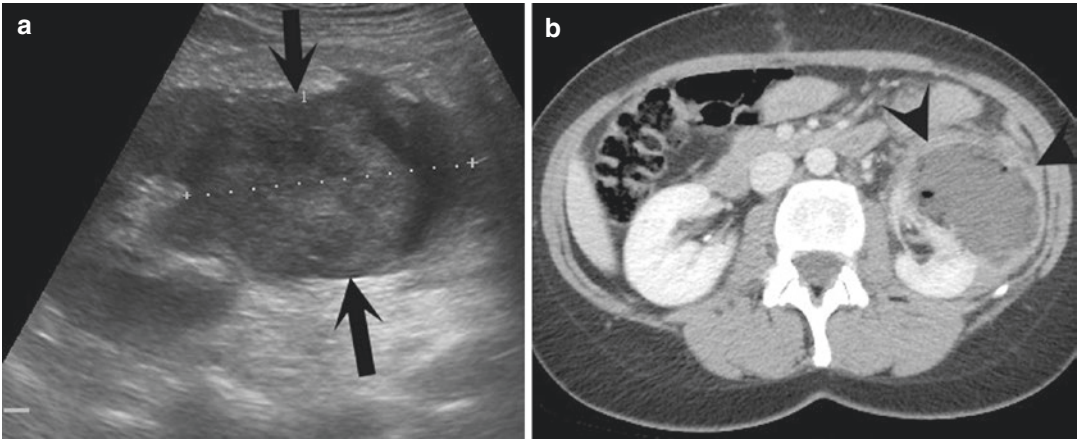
US (58.4a) demonstrated a large mass in the middle part of the left kidney (*arrows*). Immediately, he underwent a contrast enhanced CT (58.4b) that confirmed the large abscess (*arrowhead*)
